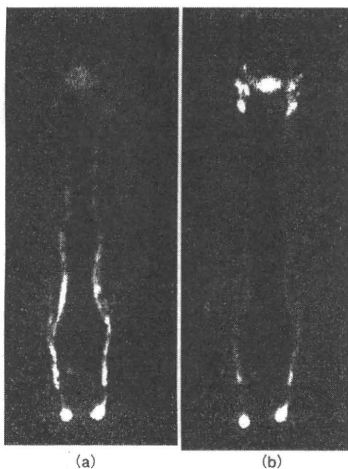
Normal lymphoscintigraphic images
